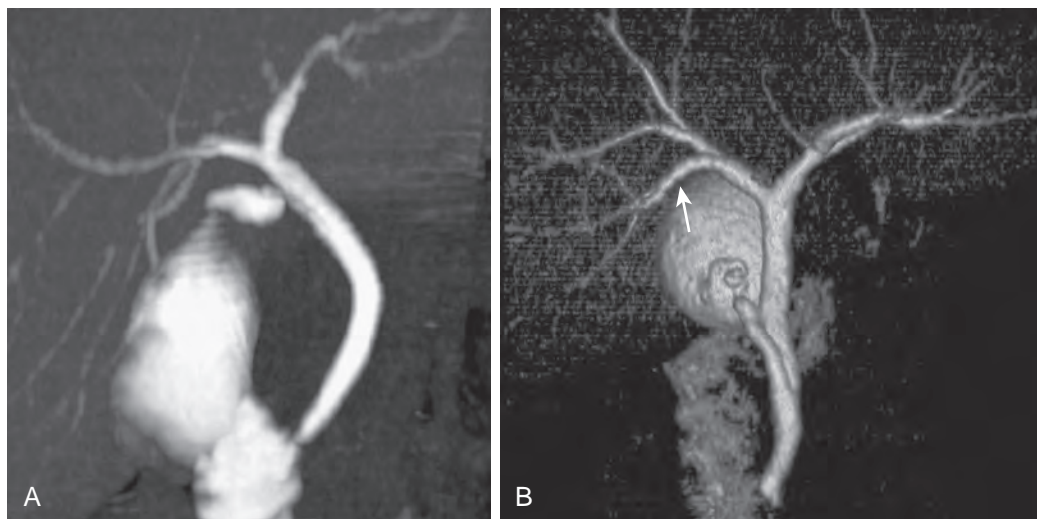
CT cholangiography. A. Coronal MIP CT cholangiogram acquired with 2.5-mm section thickness after intravenous administration of contrast material. B. Reconstructed oblique coronal volume rendered CT cholangiogram in a potential right hepatic lobe donor demonstrates normal branching anatomy of the bile ducts. (A from Wang ZJ, Yeh BM, Roberts JP, et al: Living donor candidates for right hepatic lobe transplantation: Evaluation at CT cholangiography—initial experience. *Radiology* 235:899–904, 2005. Reprinted with permission. B courtesy Benjamin Yeh, MD, and Z. J. Wang, MD.)
